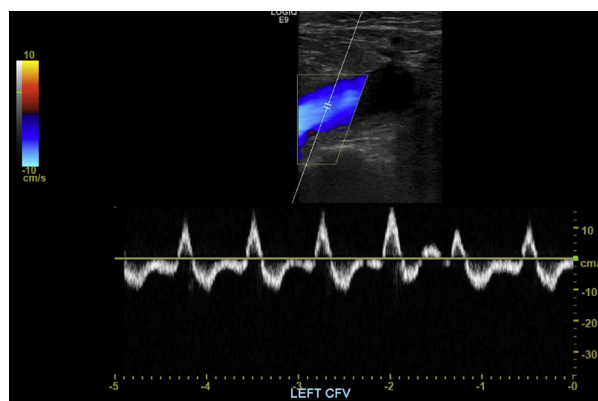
Ultrasound image of left CFV demonstrating lack of thrombus. CFV = common femoral vein.
